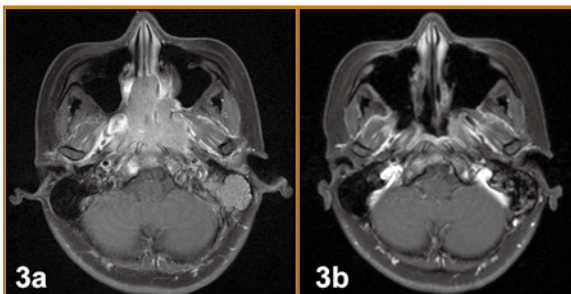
Effect of neoadjuvant CT on reduction of tumour volume in NP (a) Pre-CT MRI of NP (b) Post-CT MRI
